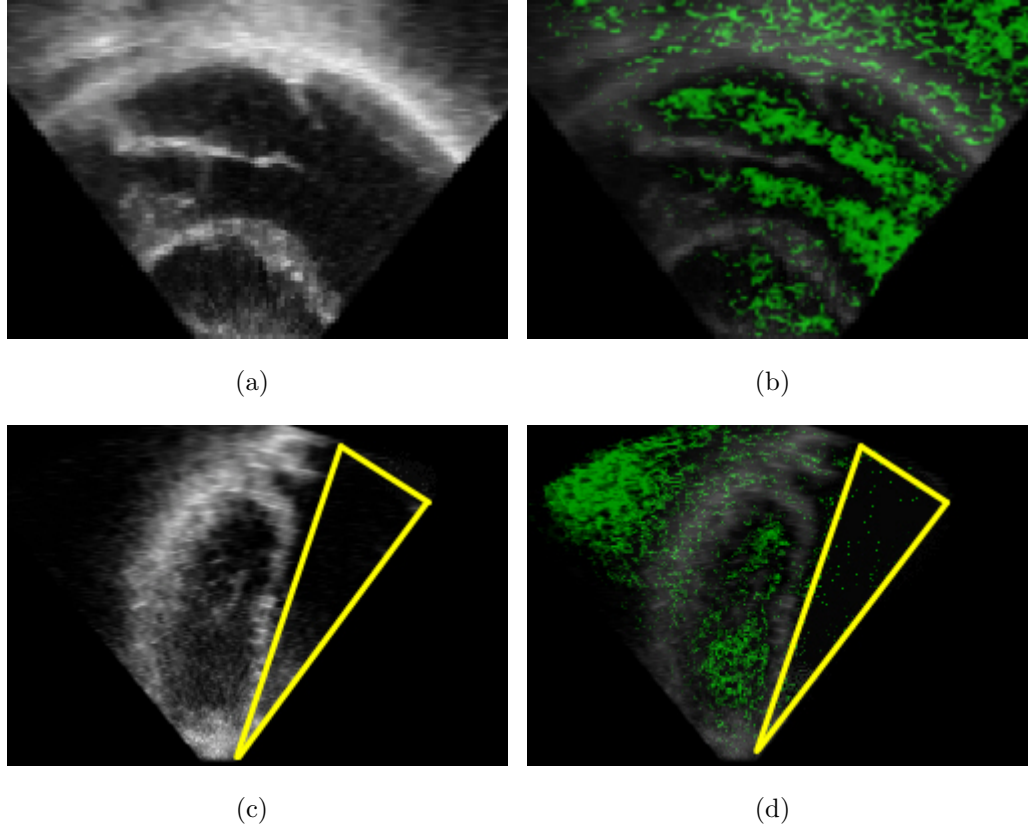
Example of regions highlighted by weight w_2 (weighting values are normalized between 0 to 1). (a) single original image slice showing the parasternal long axis view; (b) w_2 was calculated and overlaid with the original image showing the homogeneous regions; (c,d) are presented in the same way as (a,b), but with an artefact region (due to shadowing) labeled with triangle. As expected, w_2 also shows low weighting values inside the artefact region.
